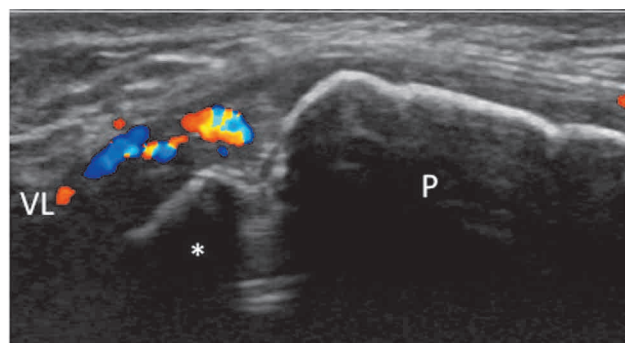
Bipartite patella, longitudinal ultrasonographic image (10 year-old male, basketball). Color Doppler ultrasonography shows neovascularization surrounding the ossicle. VL, vastus lateralis muscle, P, patella, asterisk, accessory ossicle.
